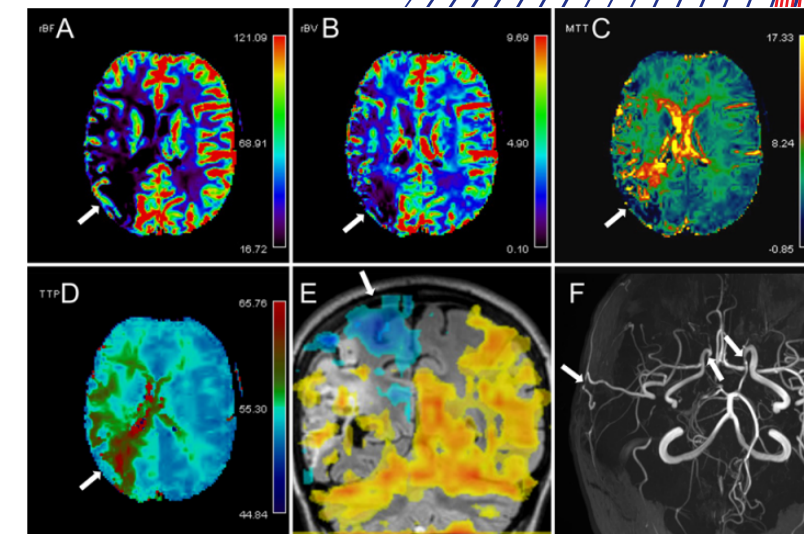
Images obtained in an adult female with MMD and a history of right STA bypass. A-D: DSC perfusion with gadolinium permits evaluation of numerous parameters, including CBF (A), CBV (B), MTT (C), and TTP (D). There is decreased CBF and CBV (arrows) compatible with a large chronic infarct in the right cerebral parietal lobe. Some vascular perfusion persists with an elevated MTT and TTP (C and D, arrows), compatible with slow delayed flow within nonviable tissue. In the bilateral ACA territory, CBF and CBV are without substantial abnormality, compatible with adequate blood supply. DSC perfusion parameters in the left MCA and left posterior cerebral artery territories are also unremarkable. E: CVR was assessed with a 20-second breath-hold BOLD response superimposed on an axial 3D T2-weighted FLAIR image, demonstrating reduced CVR in the right ACA territory as a blue overlay (arrow), compatible with vascular steal. F: Three-dimensional TOF MIP image demonstrating focal stenosis of the bilateral distal supraclinoid ICAs. The STA bypass is also visualized with mild signal loss and narrowing near the level of the calvaria (arrows) but is otherwise patent.
